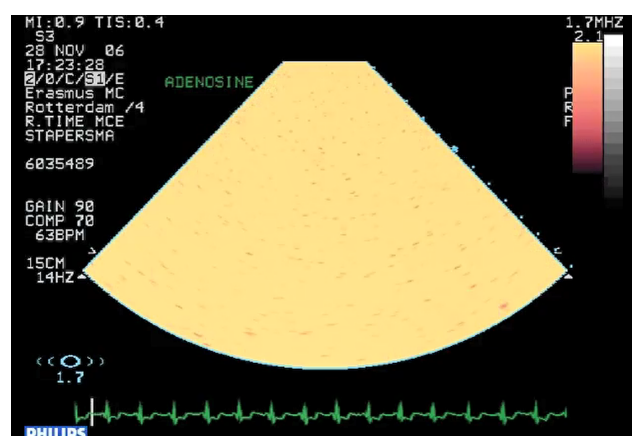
Vasodilator stress echocardiography with Adenosine, using a low-MI setting and flash-replenishment technique. (A–D) Baseline end-systolic frames before flash (A), flash (B), immediately post flash (C, myocardium is dark because of the destruction of contrast), and post-replenishment frame (D) when perfusion is again homogeneous. (E–H) After adenosine infusion, the same order of frames. (H) Post replenishment end-systolic frame demonstrating a subendocardial perfusion defect in the inferoseptal segments (arrow). Of note, during stress myocardial replenishment occurs faster than at rest because of the pharmacological vasodilation. The patient underwent coronary angiography and stent placing in the right coronary artery. Source: personal collection.
